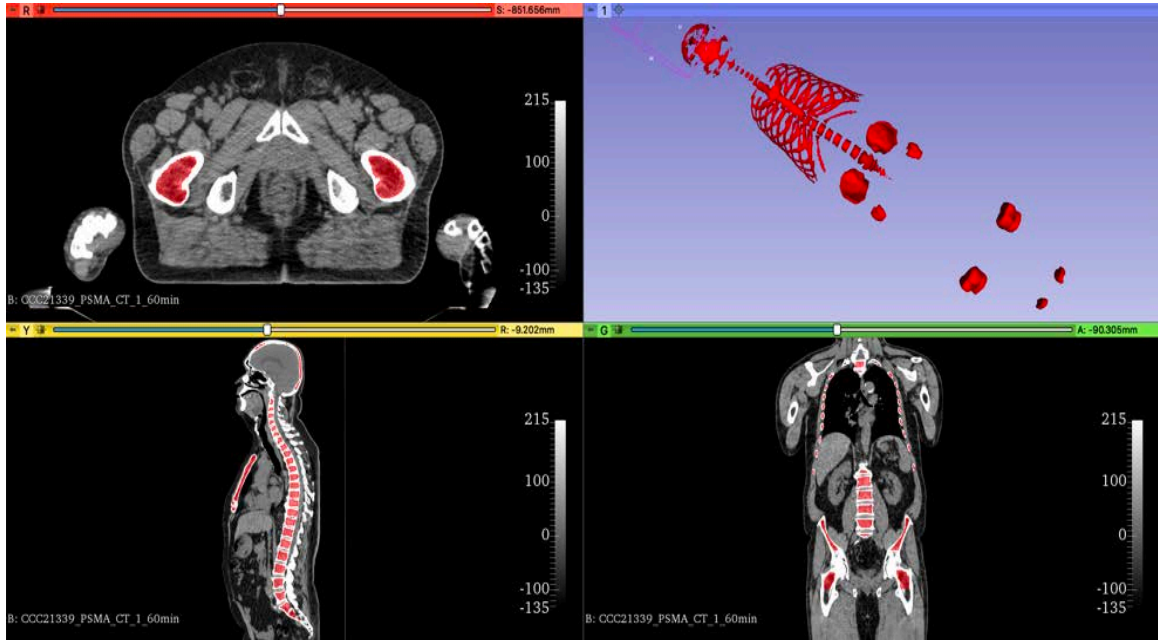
Mask created from manual segmentation of the red bone marrow in the axial (R), coronal (G), and sagittal (Y) slices of a patient CT image. A 3D view (1) of the obtained segmentation is also represented. The ‘Grey’ colormap was selected in Slicer. The color scale was adjusted to vary between black (low-density tissues) at -135 and white (high-density tissues) at 215.
